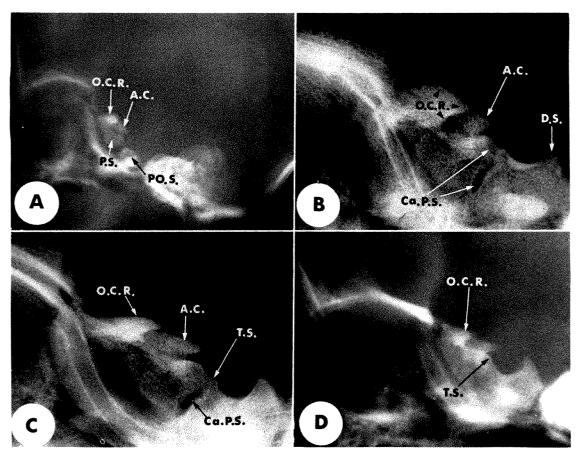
Lateral skull roentgenograms showing ossification of the presphenoid. Developmental stages comparable to those in Figure 3. (A) A 28 week fetus. The region of the future tuberculum sellae is not as yet ossified. Note the superior position of the optic canal roof (O. C. R.). A. C. = anterior clinoid process; P. S. = presphenoid; PO. S. = postsphenoid (floor of sella). (B) A 34 week fetus. The anterior sellar wall is partially ossified. Note the size and prominence of the optic canal roof (O. C. R). The "intersphenoid synchondrosis" is actually the centrally located remnant of the cartilaginous presphenoid (Ca. P. S.). D. S. = dorsum sellae. (C) A 38 week fetus. The tuberculum sellae (T. S.) is further ossified. Note the flattening of the optic canal roof. (D) Normal 2 week old infant. Note the following features of the normal newborn sphenoid; (1) a planum sphenoidale is not present; (2) the anterosuperior margin of the sellar fossa—the tuberculum sellae (T. S.) is ossified and well defined; (3) the optic canal roof is prominent and the most superior sphenoid structure.
